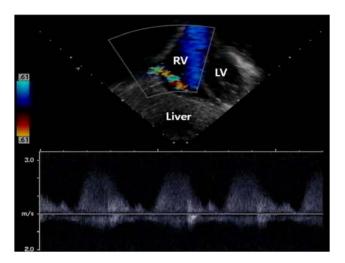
The subcostal view of color-flow imaging and the corresponding Doppler recording by echocardiography. The imaging shows an abnormal jet from the anterior wall of the right ventricle. The jet can be traced into the right ventricle.
